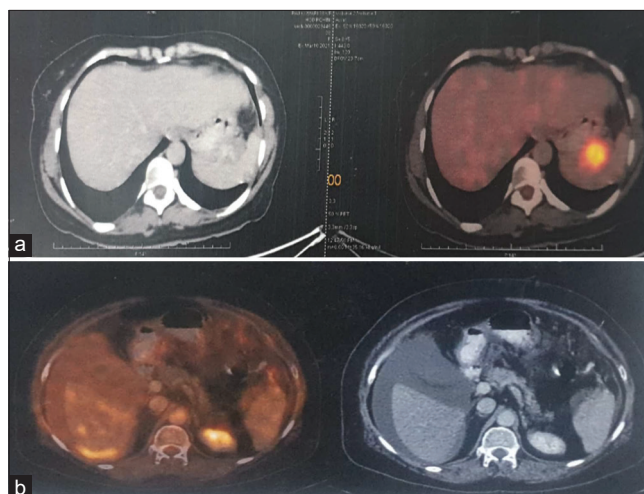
For upper abdomen disease assessment. (a) CT and PET/CT images showing perisplenic tumor deposit. (b) CT and PET/CT images showing right subdiaphragmatic deposit. PET/CT: Positron emission tomography/computed tomography
